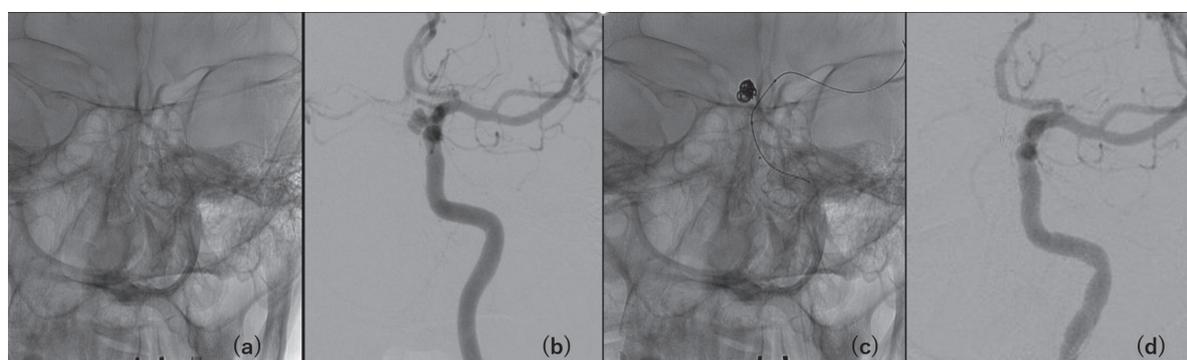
Procedure of the endovascular treatment. (a) Working angle of C-arm was detected according to the prior 3D skull CT image. (b) Proper image for coil embolization was made with Gd injection. (c) Fluoroscopy shows the aneurysm filled with platinum coils. (d) Subtraction image with Gd indicates the disappearance of aneurysm. Note the angle was detected with fluoroscopy according to the 3D-CT image. With remodeling technique, aneurysm structure is clear without roadmap. Gd: gadolinium
